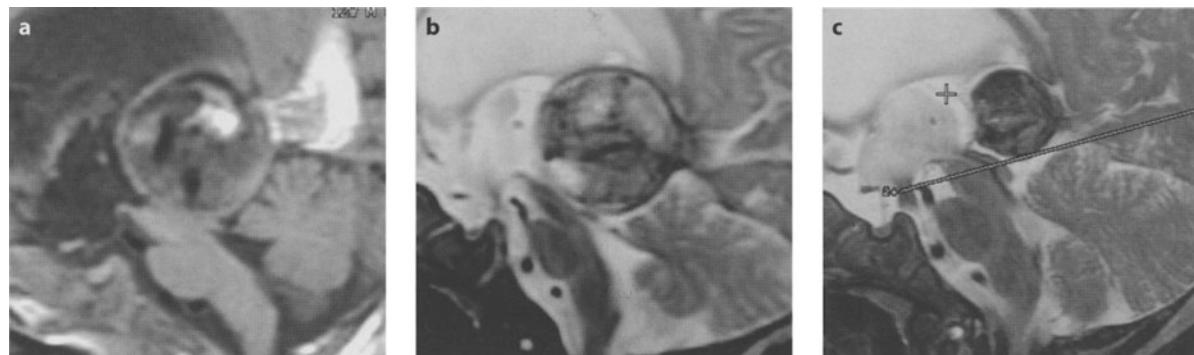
Twelve-week-old boy presenting with vein of Galen malformation diagnosed prenatally and embolized at the age of 11 weeks, admitted with symptoms and signs of intracranial hypertension. a MRI performed 5 days following embolization, showing aqueductal stenosis due to the vascular malformation and triventricular hydrocephalus. The hydrocephalus was treated the same day with third ventriculostomy. b Three weeks following endoscopic third ventriculostomy and complete resolution of the symptoms. Flow void is visible through the third ventriculostomy, the aqueduct is still compressed. c MRI performed 4 months after third ventriculostomy, showing significant decrease of the malformation and patency of the aqueduct and third ventriculostomy with CSF flow void well visible through them
